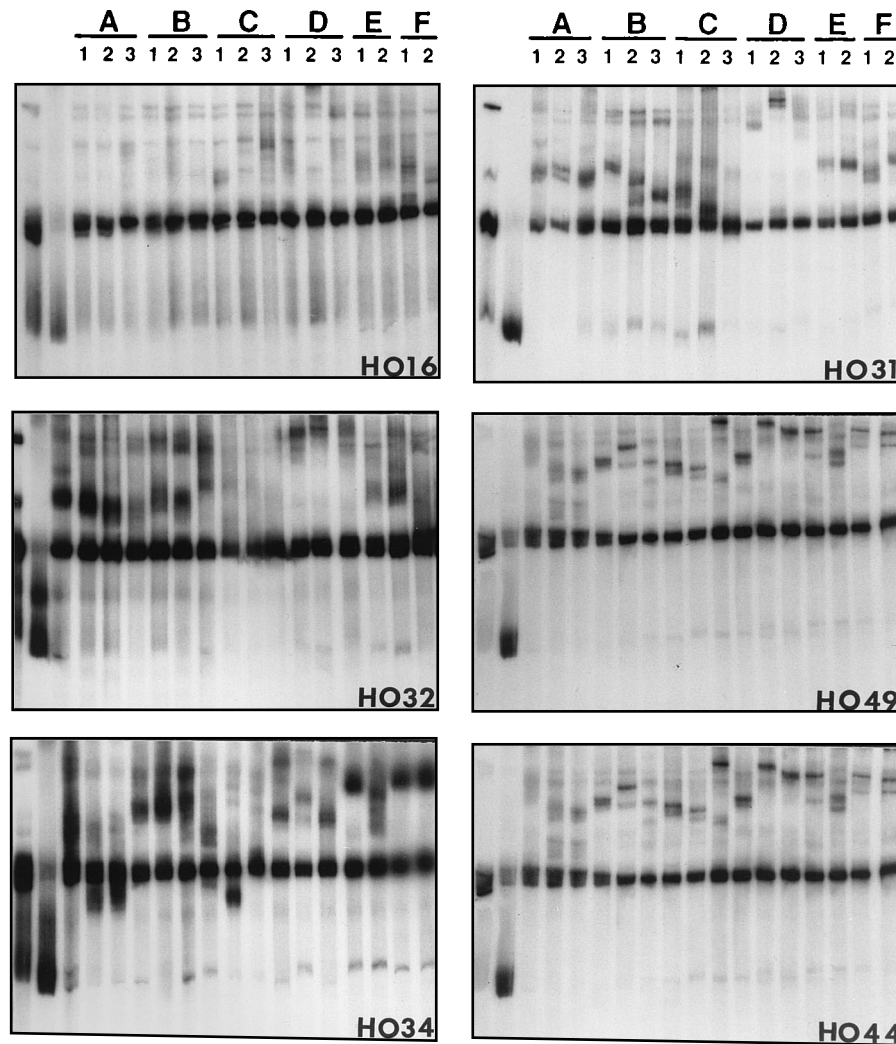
Radiographs of HMA from six representative HIV-1 patients infected with HIV-1 strains of unidentified subtype (A through F). Gel descriptions are identical to those for Fig. 1. The absence of any unambiguous fast-migrating heteroduplex double-stranded DNA bands associated with reference strains of any known subtype reveals that these patients are infected with HIV-1 strains belonging to either a new subtype(s) or divergent variants within the known subtypes.
